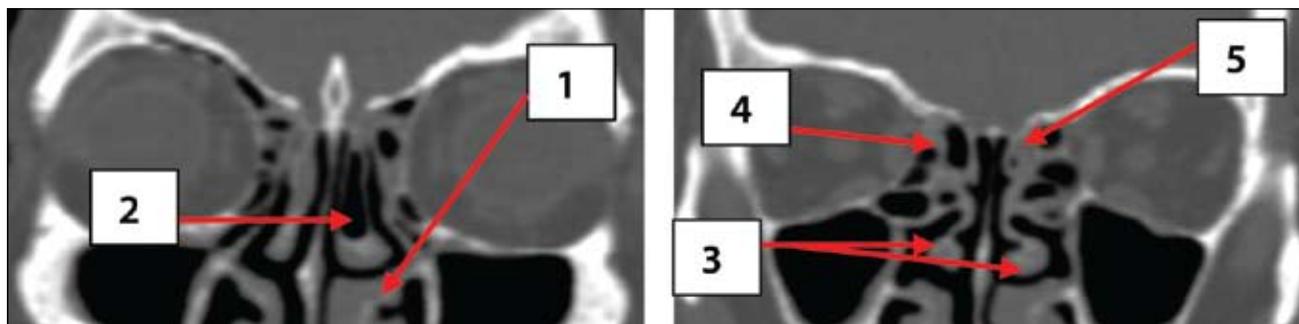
Crano-facial CT scan, coronal reconstruction. 1. frontal sinus (bilateral pneumosinus); 2. Keros type II (6.9 and 6.5 mm) variant of the ethmoid roof; 3. right concha bullosa
